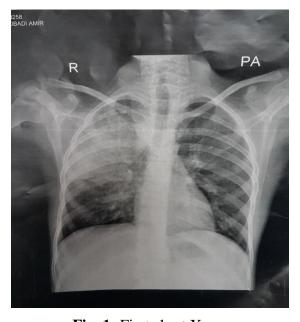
First chest X-ray
